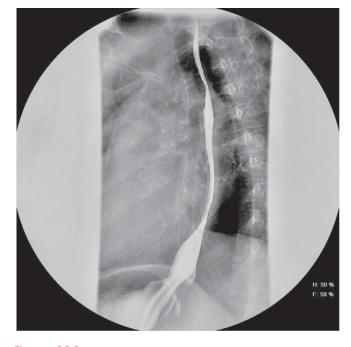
Radiographic Findings in Lichen Planus of the Esophagus. Esophogram shows diffuse esophageal narrowing and areas of more focal narrowing.
